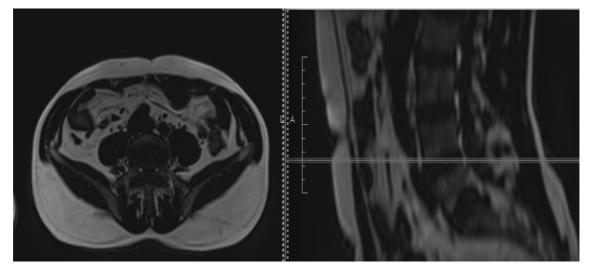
Identification of the axial MRI image that corresponds to the L4-5 anatomical position using a sagittal image. The horizontal line on the sagittal image (right) depicts the position of the axial image (left).
